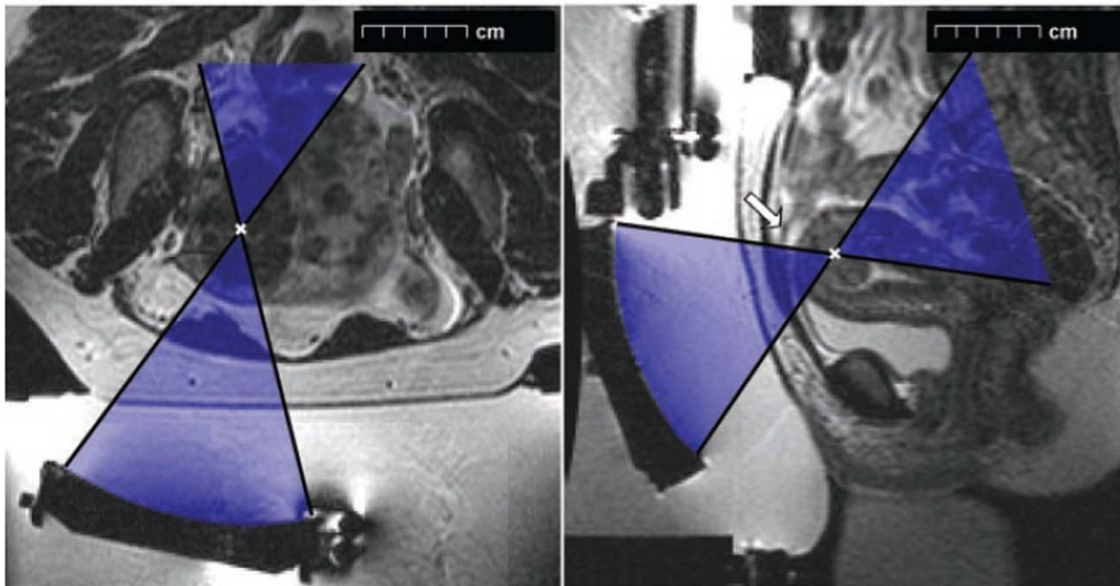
Patients 3 and 4. Transverse (left, patient 3) and sagittal (right, patient 4) T2-weighted fast SE MR images (2,500/98) with the patient in position for ultrasound surgery of uterine fibroids. In these cases, the transducer was angled during the treatment. The arrow on the right indicates the bowel loop that was avoided by angling the transducer.
